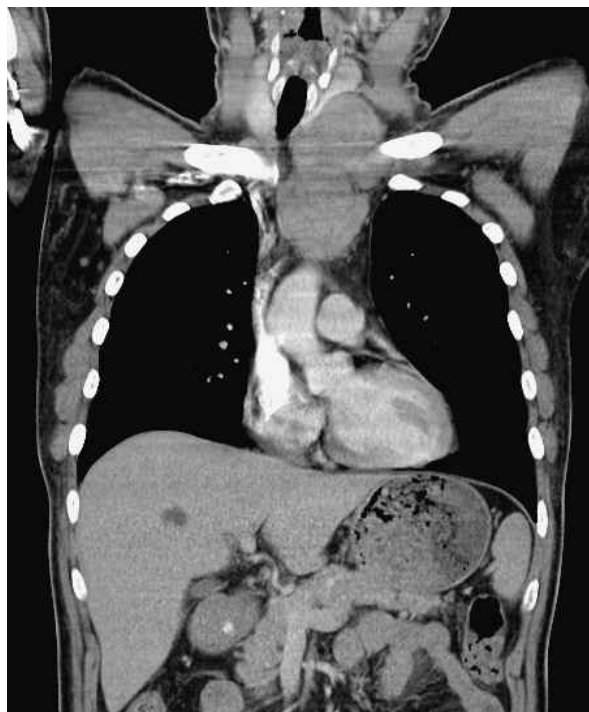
Chest CT scan showed a solid mass at the left-side thoracic inlet.
